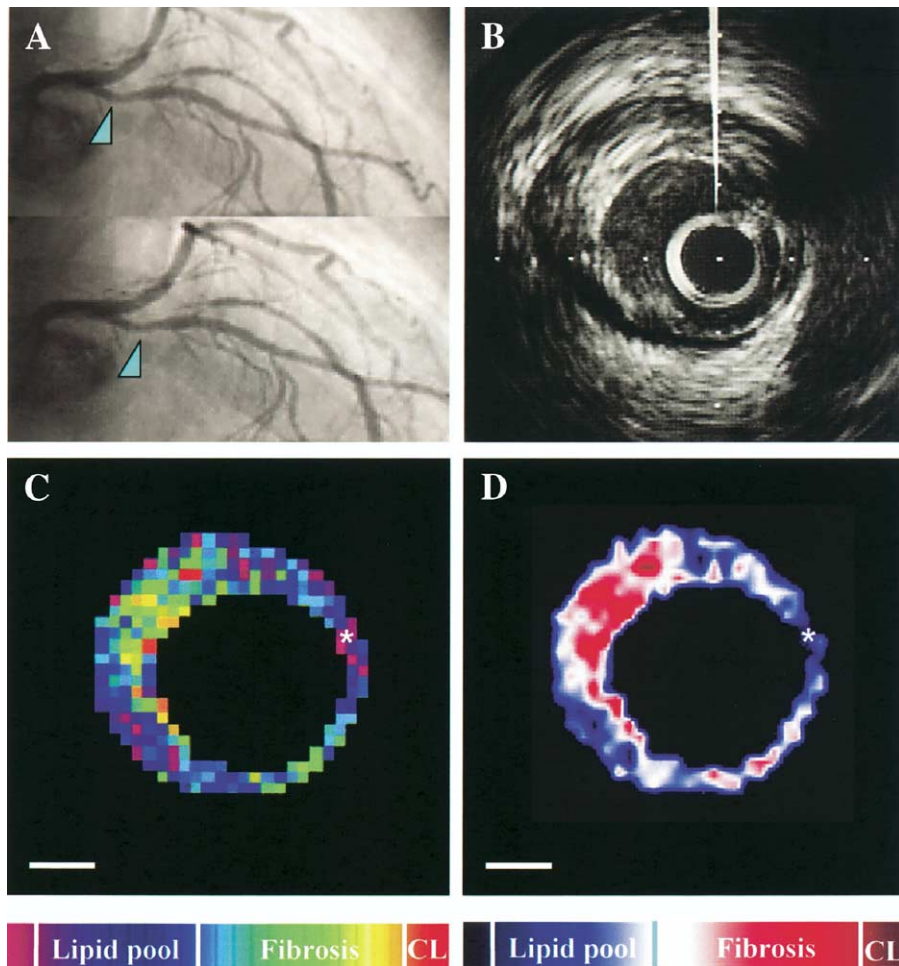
Images of the lesion not causing acute coronary syndrome. (A) Angiography of the left coronary artery. (Upper) The arrowhead indicates a lesion, in which intravascular ultrasound (IVUS) measurements were recorded at baseline. (Lower) the arrowhead indicates the segment indicated by the arrowhead at baseline after the follow-up period. (B) Conventional IVUS image of the segment indicated by the arrowhead in A. (C) Integrated backscatter (IB)-IVUS image of Cartesian coordinates, constructed using conventional color gradation, of the segment indicated by the arrowhead in A. The asterisk indicates the guidewire artifact. Note the small lipid core (blue) with large fibrous tissue (green). (D) IB-IVUS image of Cartesian coordinates, constructed using another color gradation, of the segment indicated by the arrowhead in A. The asterisk indicates the guidewire artifact. Note the small lipid core (blue) with large fibrous tissue (red or white). CL = calcification. Bar = 1 mm.
